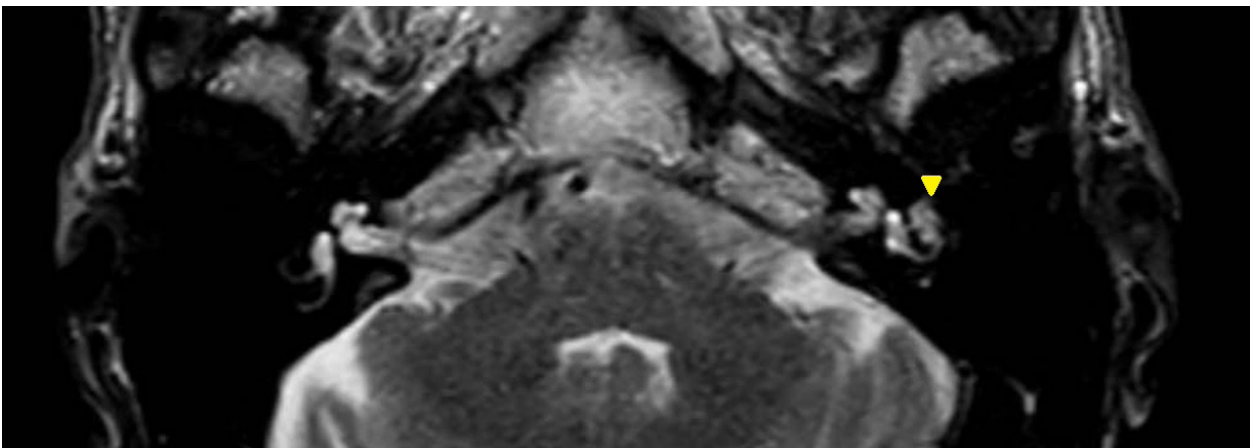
Axial T2-weighted image demonstrating an ill-defined mass lesion in the left tympanic cavity.
